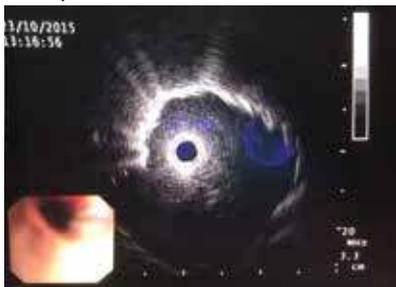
Radial Ultrasound image of a lung mass
